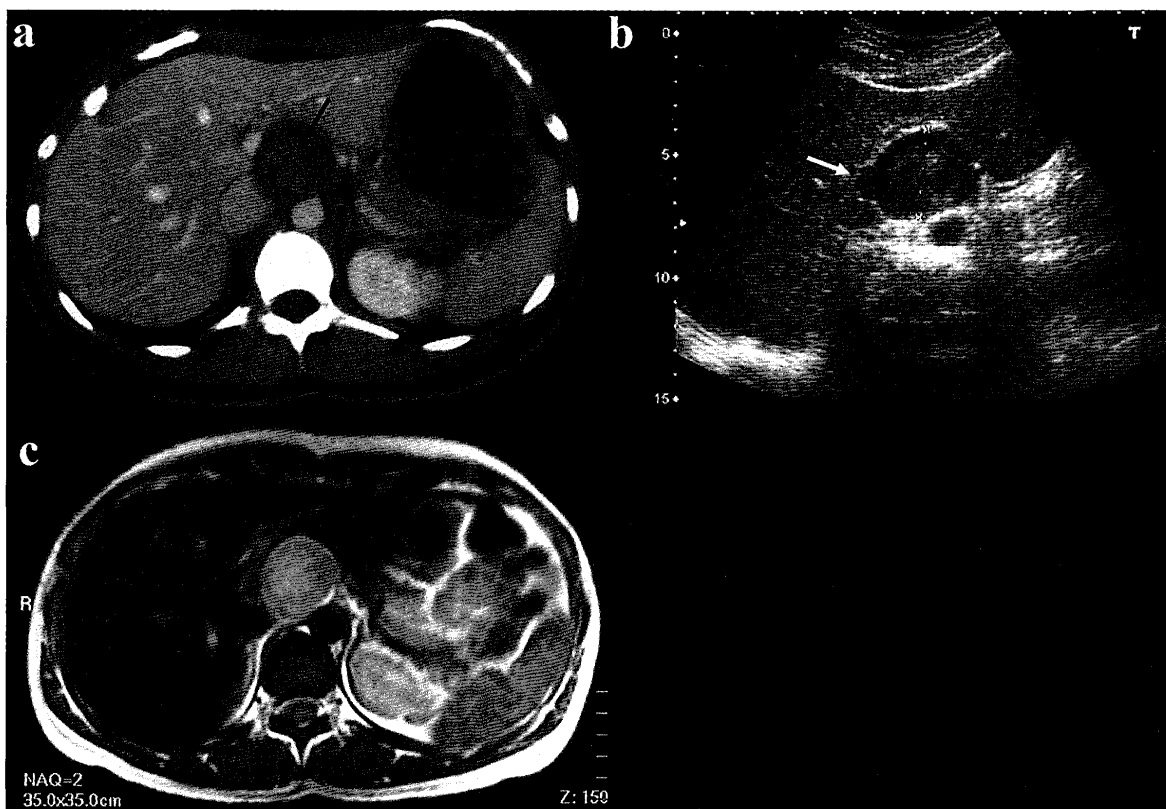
Enhanced computed tomography showing an abdominal tumor located in or adjacent to the Spiegel lobe of the liver. Arrow indicates a little central enhancement which is characteristic in benign schwannoma. (a). Ultrasonography demonstrating a heterogeneous round tumor at a size of 4 cm in diameter surrounded by aorta, porta hepatis (arrow), and lateral segment of the liver (b). Magnetic resonance T2-weighted images using Resovist[®] showing a high-intensity tumor with heterogeneous content at left side of the porta hepatis (c).
